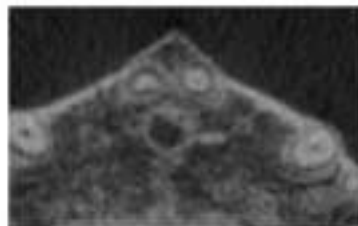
Contact of upper incisor's root with incisal canal CBCT.
